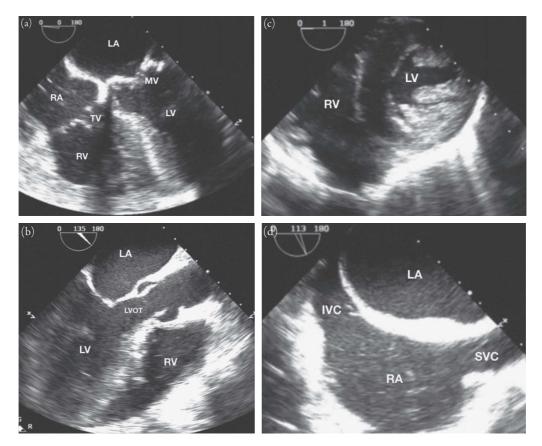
(a) Transesophageal echocardiography, mid-esophageal 4-chamber view. RA = right atrium; RV = right ventricle; LA = left atrium; LV = left ventricle; TV = tricuspid valve; MV = mitral valve. (b) Transesophageal echocardiography, mid-esophageal long axis view. RV = right ventricle; LA = left atrium; LV = left ventricle; LVOT = left ventricular outflow tract. (c) Transesophageal echocardiography, trans-gastric short axis view. RV = right ventricle; LV = left ventricle. (d) Transesophageal echocardiography, bicaval view. RA = right atrium; LA = left atrium; IVC = inferior vena cava; SVC = superior vena cava.
